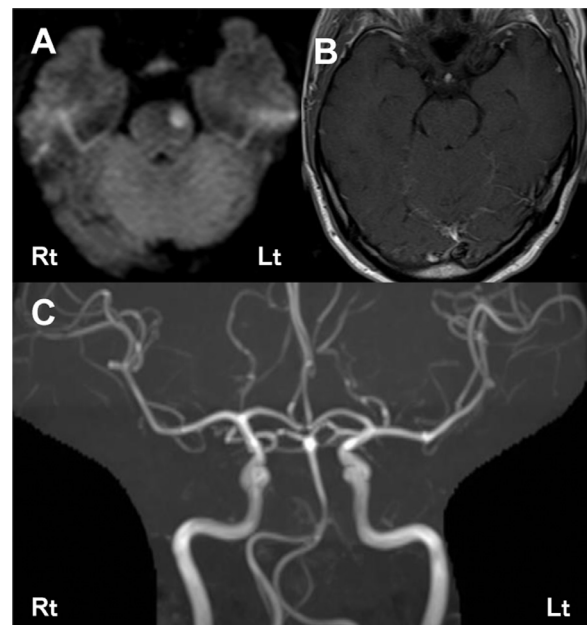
Diffusion-weighted MRI in Case 2. Diffusion-weighted MRI on admission revealed an acute infarct in the left lateral medulla. MRI indicates magnetic resonance imaging.
